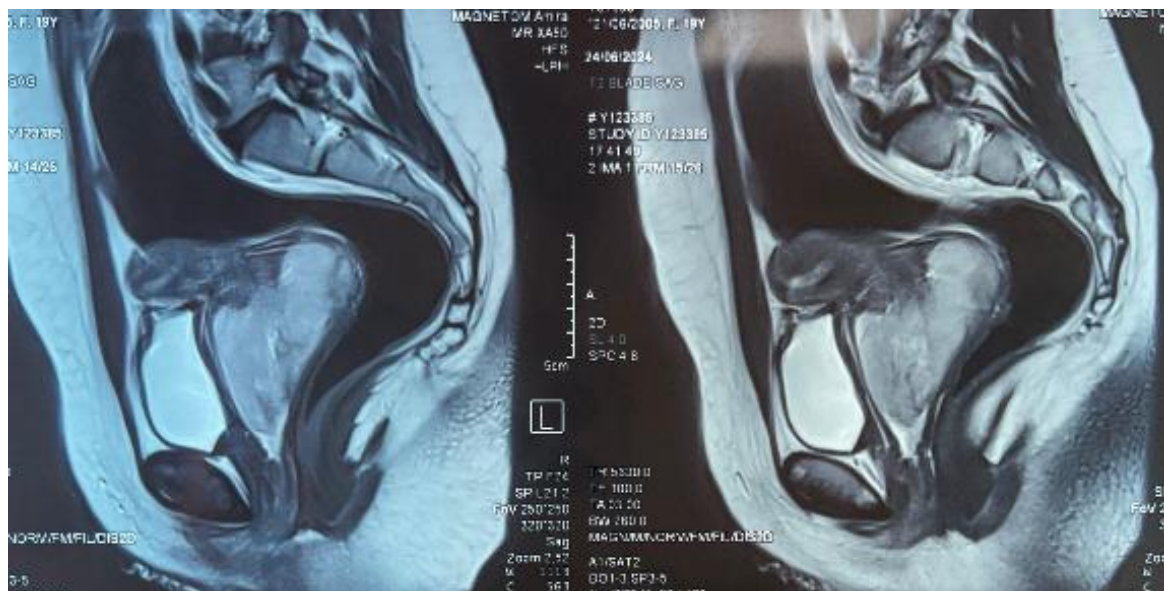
Sagittal pelvic MRI (T2-weighted sequence) showing a bulky compressing adjacent structures with loss of the fat interface with the bladder and rectum
